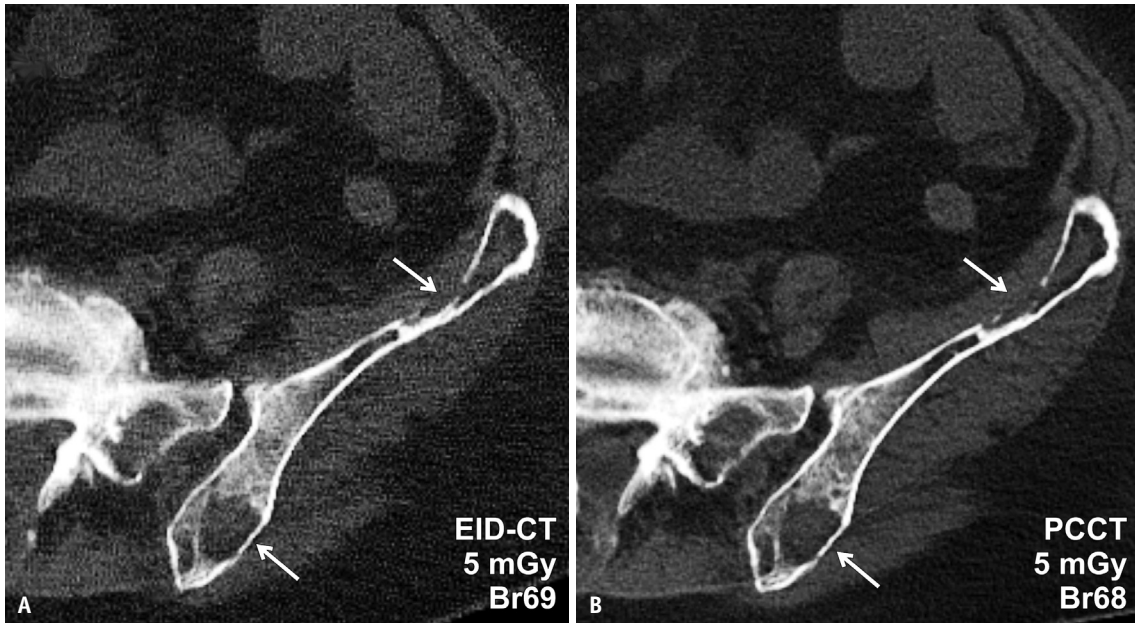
Standard-resolution whole-body low-dose CT scans with EID (A) and photon-counting detector (B) technology depict two osteolytic lesions in the left iliac bone (arrows) of a 69-year-old male with multiple myeloma. Note the substantially higher image noise level in EID-CT despite comparable acquisition and reconstruction settings. EID = energy-integrating detector, PCCT = photon-counting computed tomography
